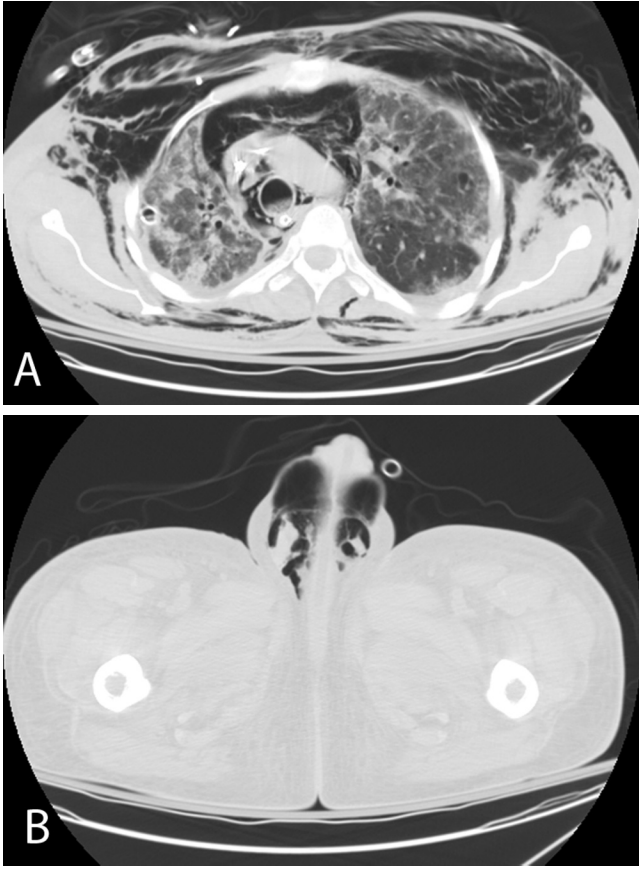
38-year-old male with metastatic choriocarcinoma. A. Transverse CT images of the chest and mediastinum obtained seven days later demonstrate interval development of severe pneumomediastinum and massive subcutaneous emphysema. B. The subcutaneous emphysema has dissected inferior into the inguinal canals and scrotum.
